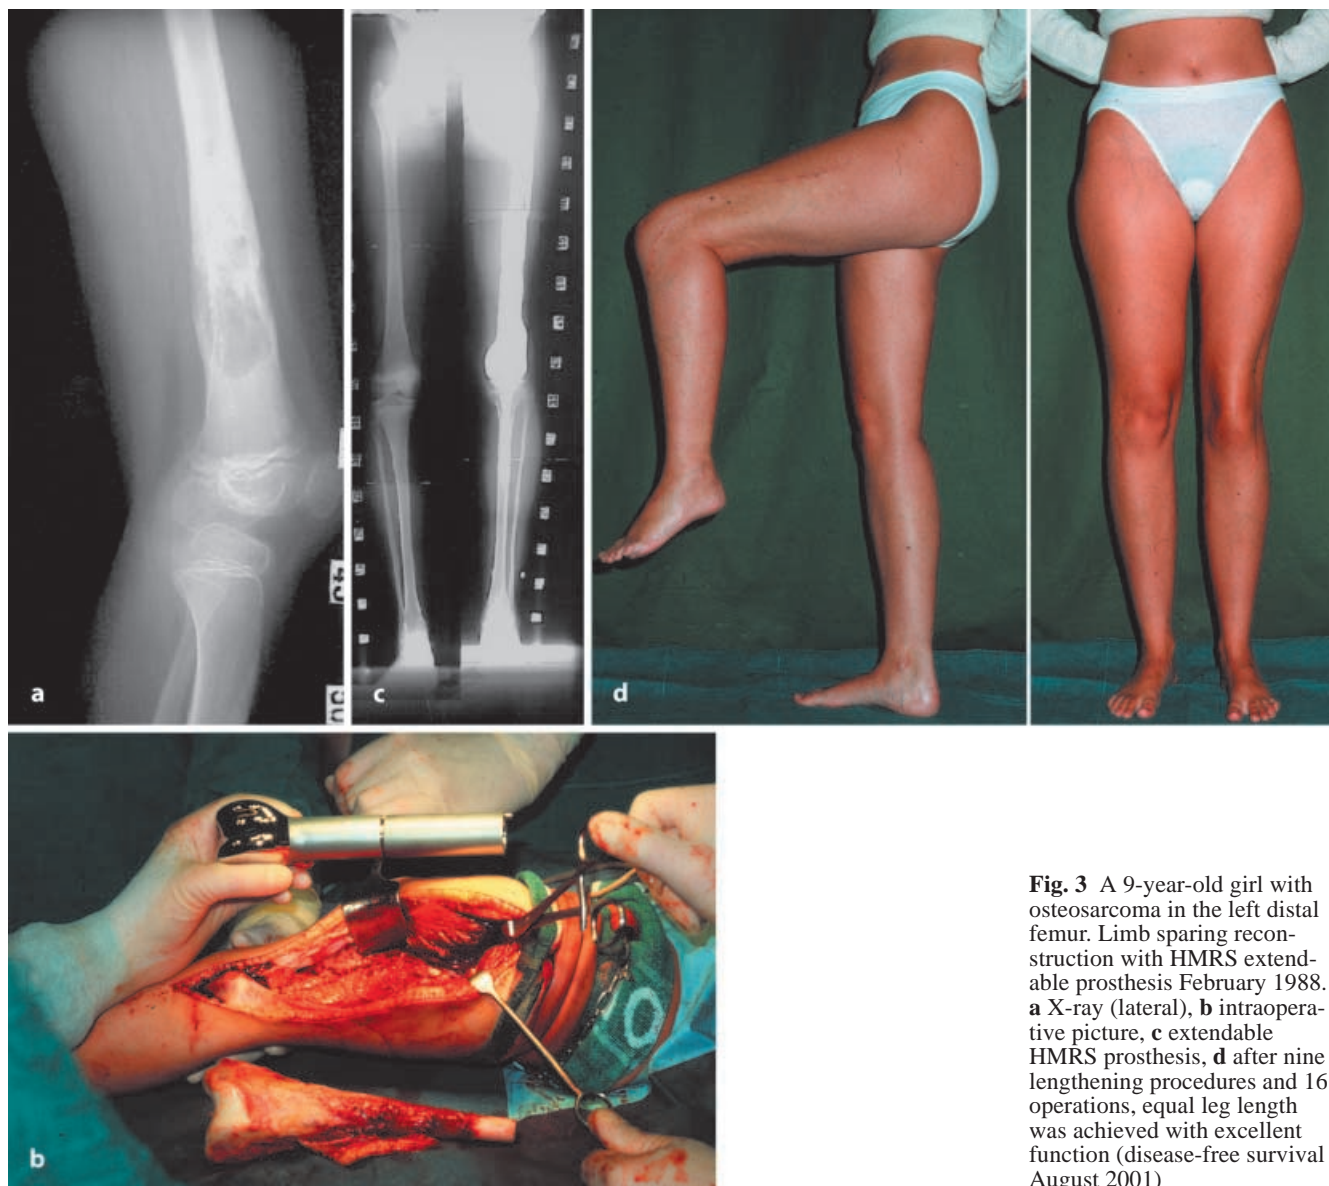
A 9-year-old girl with osteosarcoma in the left distal femur. Limb sparing reconstruction with HMRS extendable prosthesis February 1988. a X-ray (lateral), b intraoperative picture, c extendable HMRS prosthesis, d after nine lengthening procedures and 16 operations, equal leg length was achieved with excellent function (disease-free survival August 2001)
